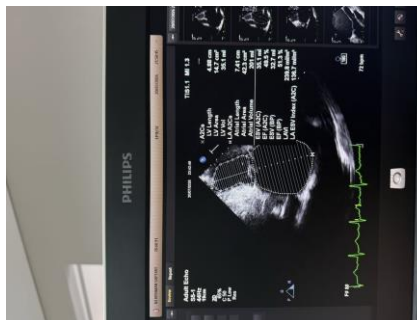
Two-dimensional echocardiographic assessment demonstrating severe left atrial enlargement, with a left atrial volume index of 239.8 mL/m².
